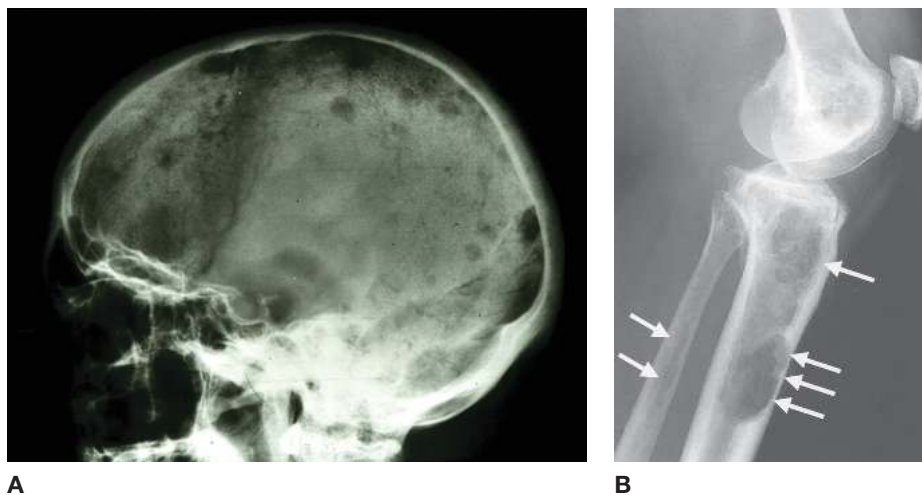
Multiple myeloma. (A) Radiograph of the skull showing “punched out” osteolytic lesions characteristic of multiple myeloma. (B) Lateral view of the tibia and fibula showing focal lytic lesions (arrows). (Image A reproduced with permission from Kantarjian HM et al. *The MD Anderson Manual of Medical Oncology*, 2nd ed. New York: McGraw-Hill, 2011, Fig. 11-2. Image B reproduced with permission from Lichtman MA et al. *Williams Hematology*, 8th ed. New York: McGraw-Hill, 2010, Fig. 109-13A.)
